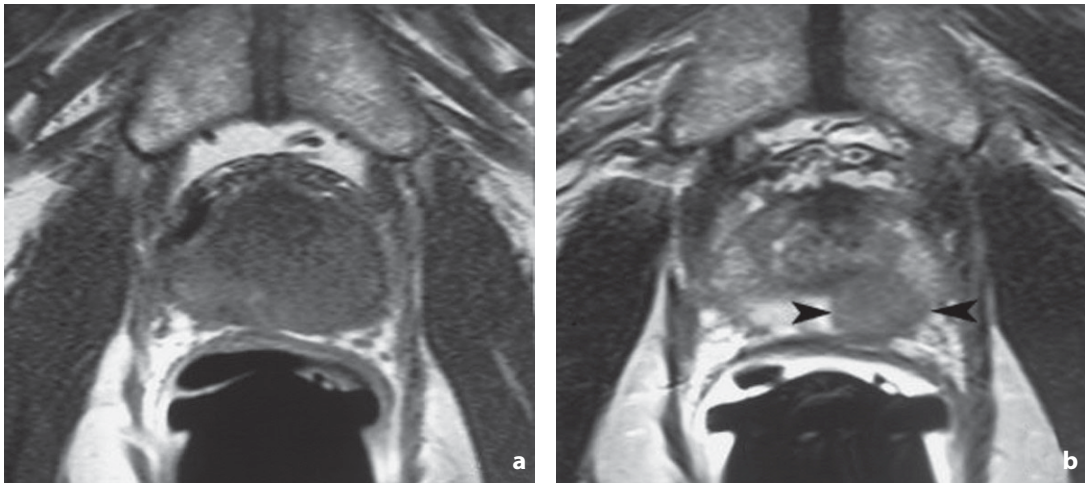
Magnetic resonance. Signal characteristics. Prostatic carcinoma. a Axial T1-weighted image. The lesion is isointense to the adjacent tissue and therefore cannot be identified. b Axial T2-weighted image shows the well-defined hypointense nodule (*arrowheads*) in the context of the hyperintense peripheral zone
